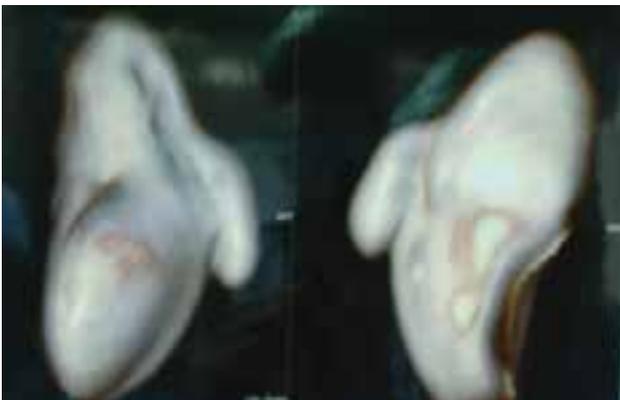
3D CT reconstruction of the scaphoid
